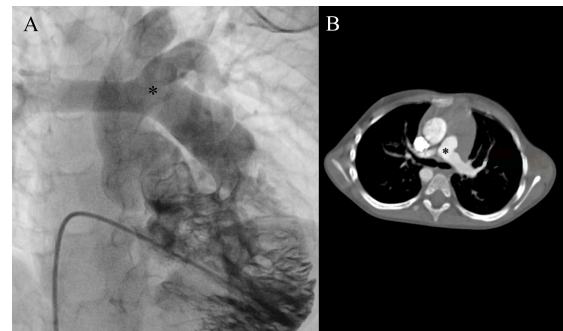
A: Invasive angiocardiology- right ventriculogram showing normal sized confluent pulmonary artery branches (*) in a patient with Tetralogy of Fallot; B: Computed tomography-Multi-planar reformation image showing normal sized confluent pulmonary artery branches (*) in a patient.
